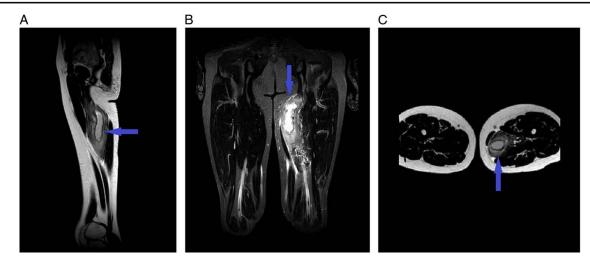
MRI showing left adductor pyomyositis in T1 (A), Short Tau Inversion Recovery (STIR) (B), and T2 (C) sequences.
